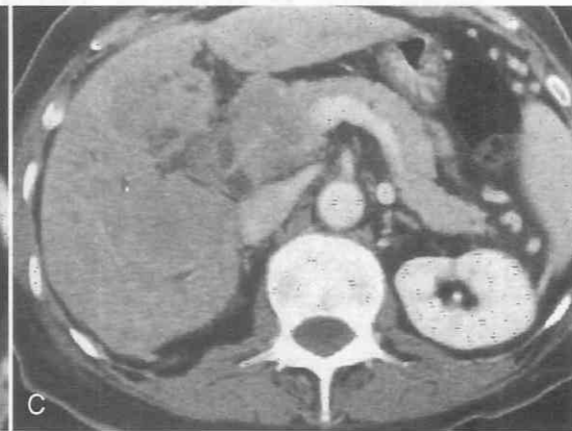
FSSE (TR = 500 msec, TE = 150 msec) images in a 62-year-old woman with pancreatic cancer. A, The MR images of the body of the pancreas are unremarkable. B, A low-signal-intensity, non-contour-deforming lesion (*arrow*) in the head proved to be cancer at surgery. C, Noncontrast 5-mm CT scan does not demonstrate the non-contour-deforming pancreatic cancer. (From Semelka RC, Kroeker MA, Shoenut JP, et al: Pancreatic disease: Prospective comparison of CT, ERCP, and 1.5-T MR imaging with dynamic gadolinium enhancement and fat suppression. *Radiology* 181:785-791, 1991.)
